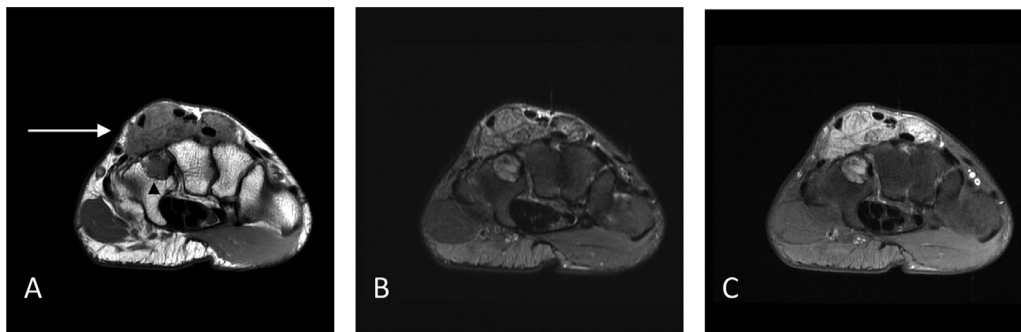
(A) – Axial T1-weighted nonfat-suppressed MRI of the hand demonstrating a lobulated mass (white arrow) of intermediate signal intensity at the dorsal aspect of the distal carpus with close association of the extensor tendons and abnormal focal signal (black arrowhead) in the dorsal aspect of the hamate. (B) Axial T2-weighted fat saturated MR image at the same level shows the lesion to be mixed signal but primarily hyperintense. (C) Axial T1-weighted fat-saturated postcontrast image shows considerable enhancement of the mass.
